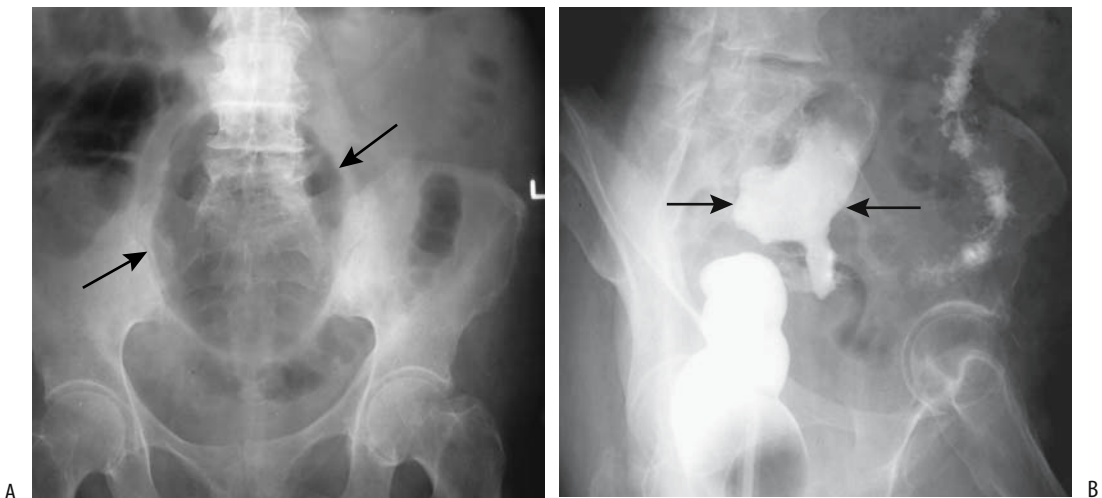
Giant sigmoid diverticulum. A: A conventional radiograph identifies a large gas-filled structure (arrows). B: A barium enema confirms a diverticulum (arrows) and establishes its communication with colon.
